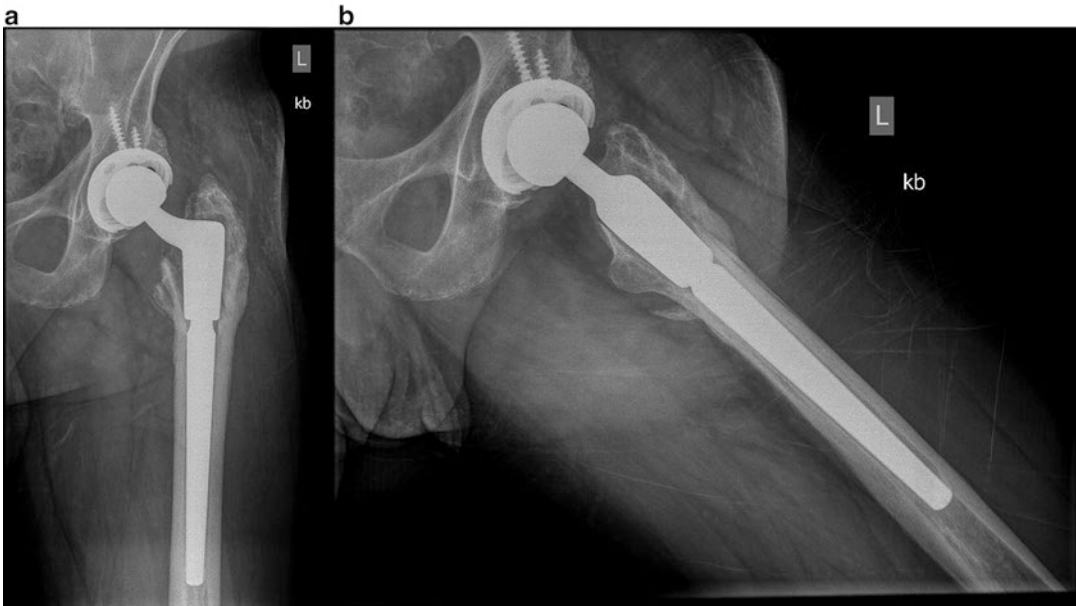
Post-revision (a) anteroposterior (AP) and (b) lateral radiographs with a revision modular fluted tapered stem
